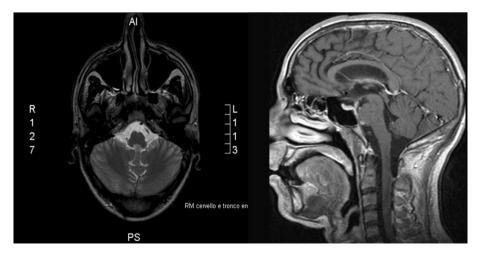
Sagittal and coronal T1-weighted gadolinium-enhanced magnetic resonance scan of the brain of our patient with *Asper- gillus flavus* meningitis showing contrast impregnation along the basilar artery in the prepontine cistern.
